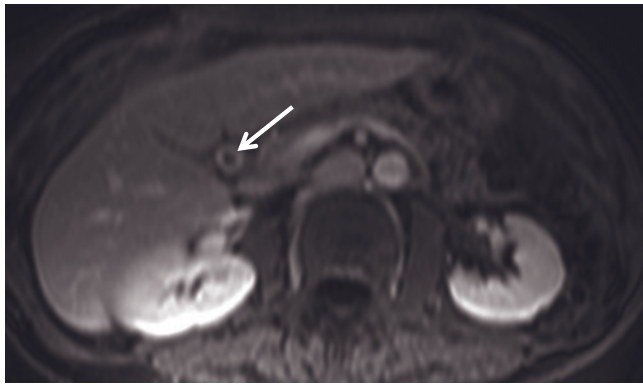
Extrahepatic cholangiocarcinoma. Coronal T2-weighted thin-section MRCP single-shot echo-train spin-echo image with fat suppression (*a*) and transverse T1-weighted GE (*b*) and 2-minute postgadolinium fat-suppressed GE (*c*) images. Obstruction of the proximal CBD (arrow, *a*) is present, showing an abrupt cut-off ("shoulder sign") on the MRCP image (*a*). The intrahepatic biliary tree is markedly dilated (*a*). The extrahepatic cholangiocarcinoma shows circumferential growth along the dilated proximal CBD (arrows, *b*, *c*). On the late postgadolinium image (*c*), the tumor shows intense enhancement (arrow, *c*) and can be differentiated from adjacent liver parenchyma.
